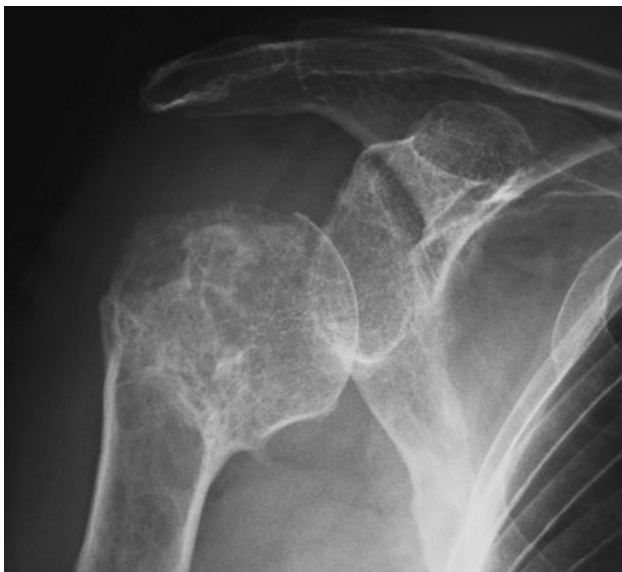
Postoperative AP X-rays corresponding to the case are shown in Fig. 1. Complete removal of the impinging proximal portion of the greater tuberosity may be seen
